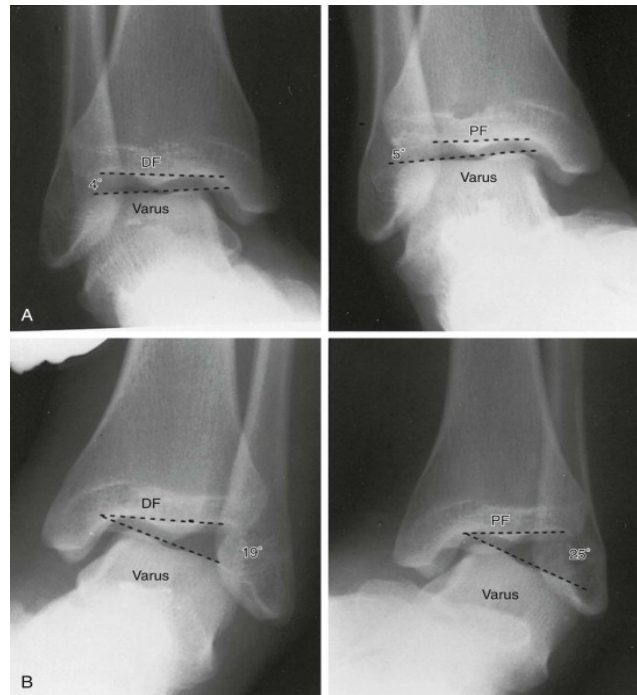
Examining talar tilt using radiographs: A, Normal tilt; B, abnormal tilt; DF, dorsiflexion, PF, plantarflexion (Coughlin et al., 2014).
